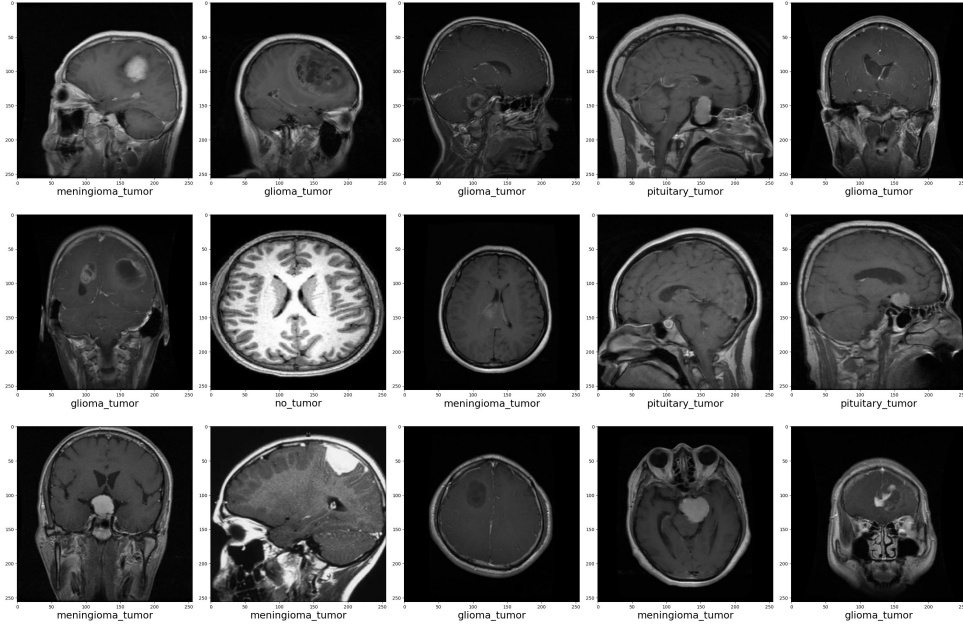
Sample MRI images in the Brain Tumor MRI dataset.
